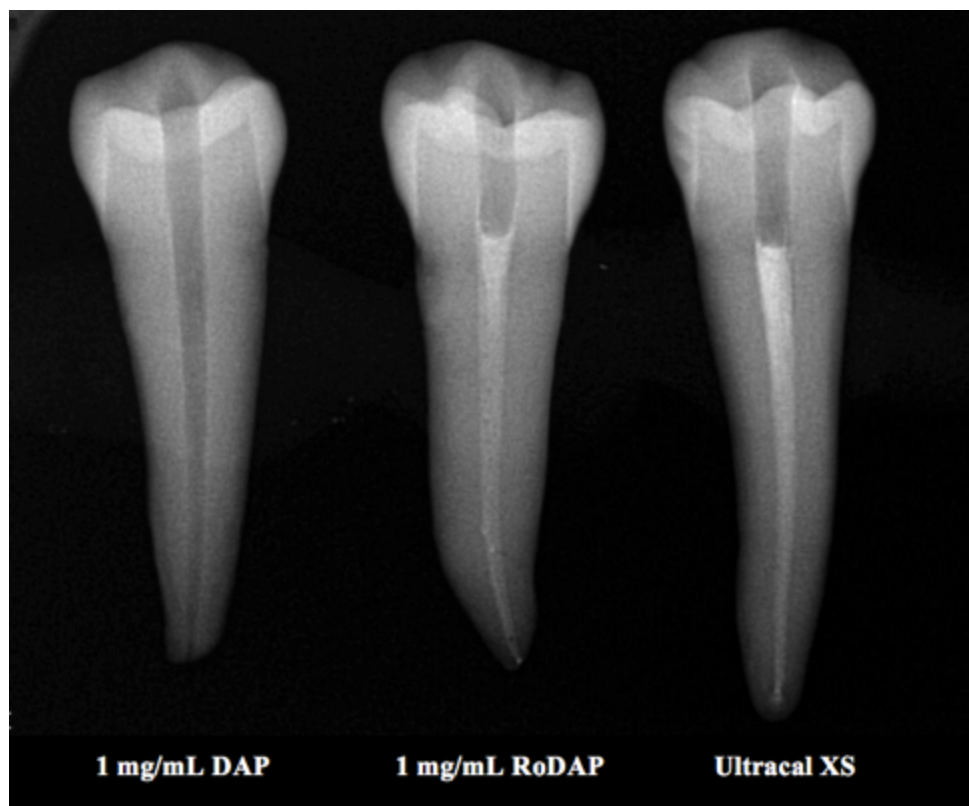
Radiograph demonstrating similar radiopacity of 1 mg/mL RoDAP compared with Ultracal XS when 30% w/v barium sulfate was added to DAP as a radiopacifying agent.
